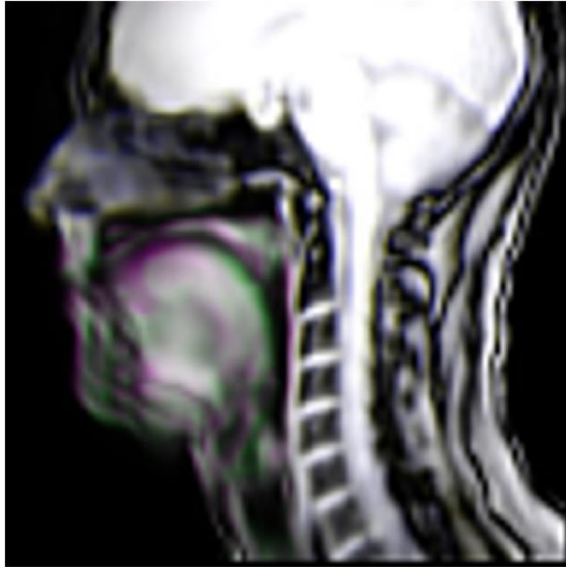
Coloured regions show mismatches between two (French vs English) overlaid mean MRI images while the speaker reads “The North Wind and the Sun” in each language (speech and pauses are included). Red regions show articulator placement in French but not in English; green regions show the opposite.
